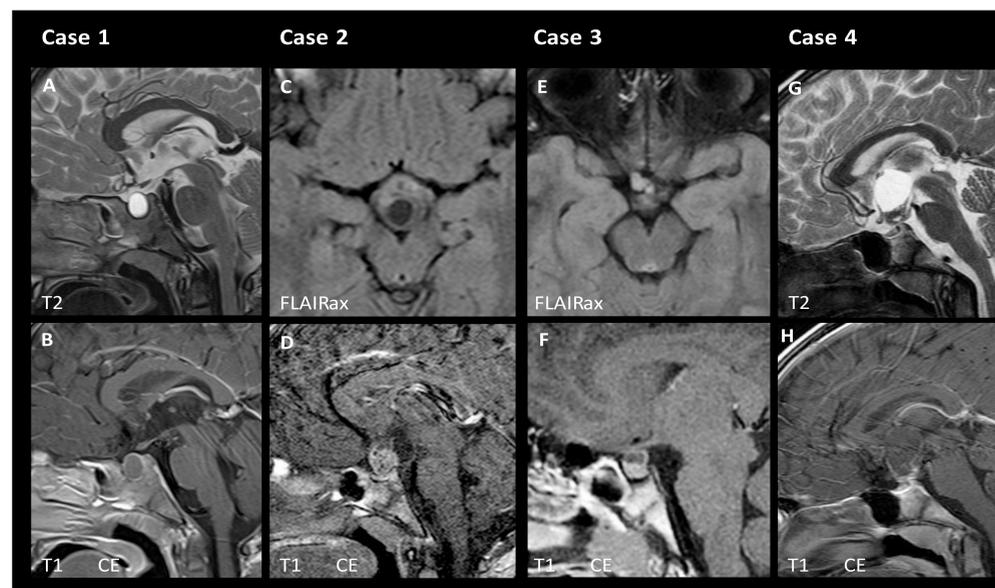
MRI at diagnosis in 4 patients (Figure 1 A–H) diagnosed and recruited with incidentaloma craniopharyngioma (incCP) in the trial KRANIOPHARYNGEOM 2007 between 2007 and 2014. Figure 1A,B (Case 1): Small, predominantly intrasellar and cystic lesion, displacing the sellar diaphragm upward, no contact to the optic system. Figure 1C,D (Case 2): Medium sized, partly solid, partly cystic lesion compressing the optic chiasm as well as the anterior and posterior hypothalamus, primarily located in the suprasellar region, edema of the tractus opticus. Figure 1E,F (Case 3): Small, partly solid, partly cystic lesion with an intra- and suprasellar location, displacing the optic chiasm slightly upward. Figure 1G,H (Case 4): Medium sized, mostly suprasellar and cystic lesion with compression of the anterior and posterior hypothalamus. Additionally bleeding in a small Rathke's cleft cyst. In all cases, the solid parts and the cyst walls show some contrast enhancement and the cyst content some elevated signal on T1 due to protein-rich and colloid content.
